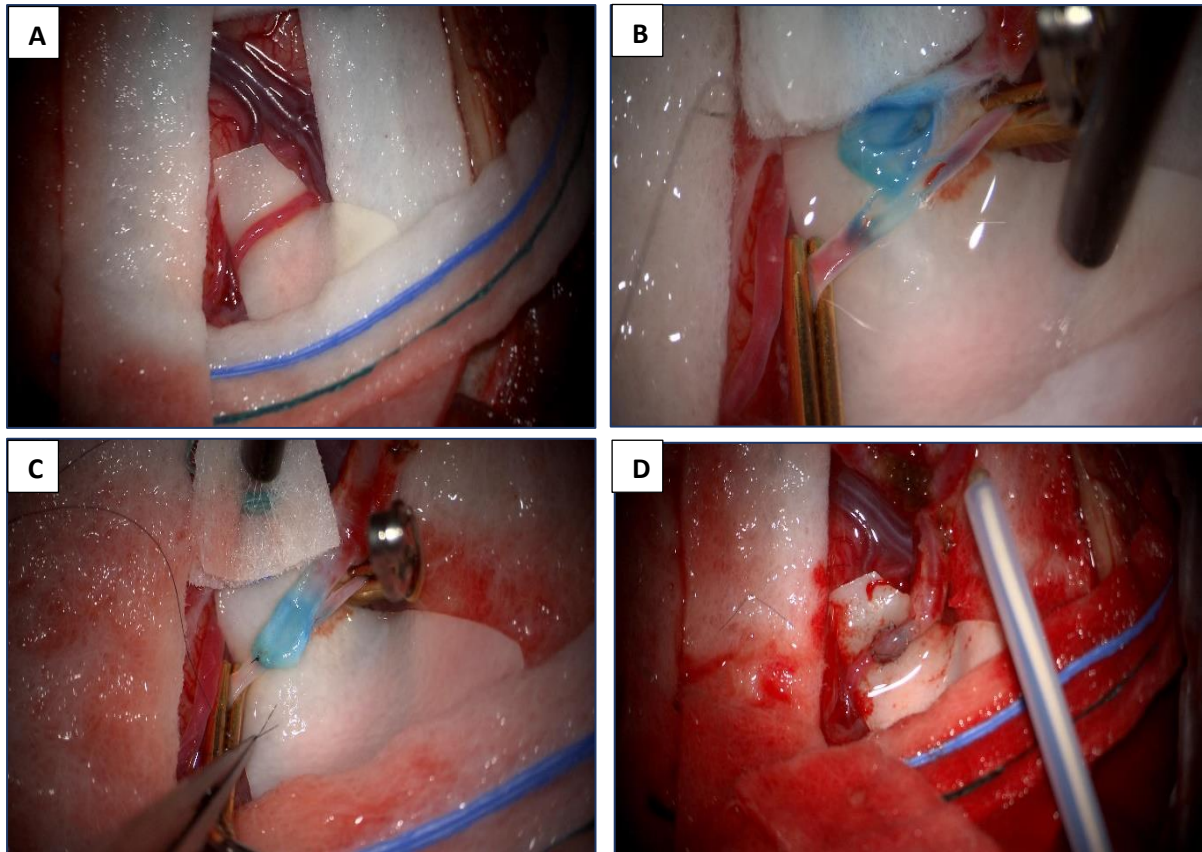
(A-D): Preparation of recipient artery and anastomosis. A- Cortical branch of Middle Cerebral Artery identified, dissected, and skeletonized. B-Arteriotomy done over MCA C-End to side anastomosis done using Prolene 10/0 suture. D-Anastomosis completed and patency checked with intra-operative Doppler
